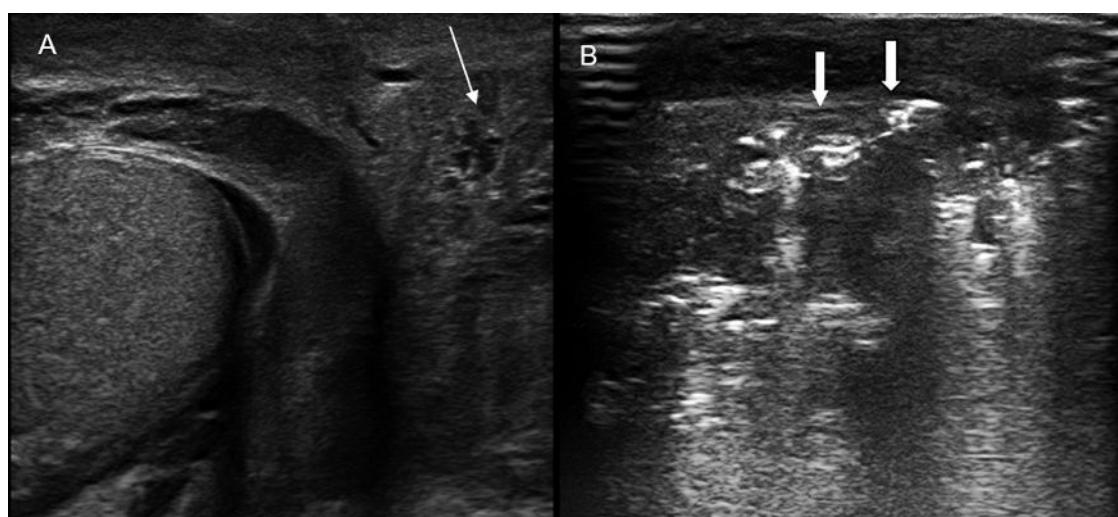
(A) Scrotal wall cellulitis: Scrotal wall thickening with anechoic to hypoechoic areas (thin arrow). (B) Fournier's gangrene: Subcutaneous gas within the scrotal wall seen as numerous discrete hyperechoic foci with reverberation artefacts (thick arrows), the sonographic hallmark.
